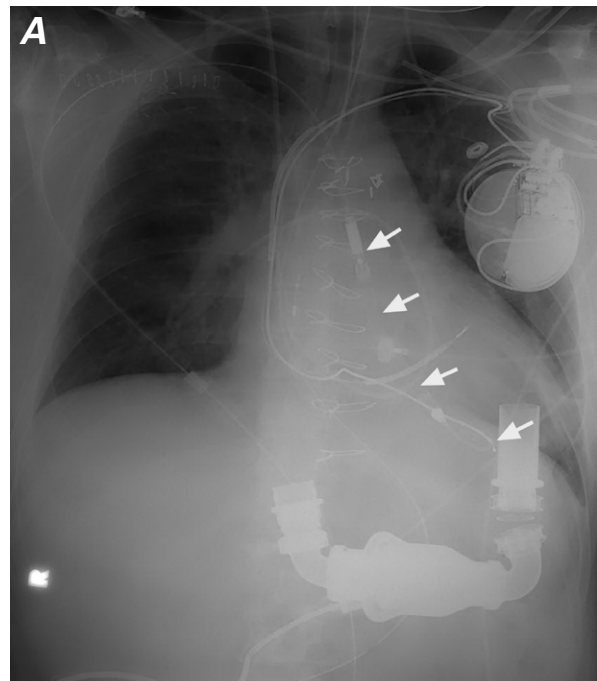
The Impella 5.0 (arrows) inserted in our patient is shown on A) a chest radiograph and B) a transesophageal echocardiogram.
